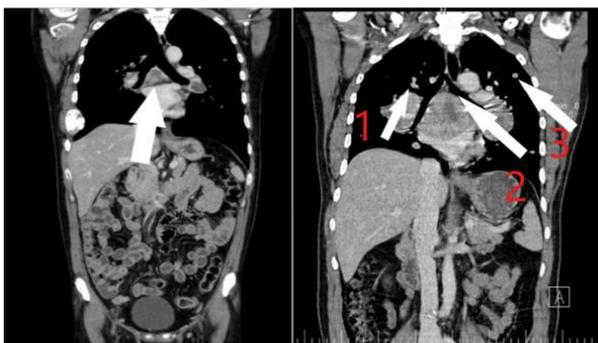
Chest CT images demonstrating radiologic response to mediastinal IMRT in metastatic FTC. Right: Pre-treatment CT showing numerous bilateral pulmonary metastatic nodules (largest approximately 45 mm) and a bulky subcarinal lymph node measuring 50 × 70 mm. Left: Follow-up whole-body CT performed months after scapular metastasis work-up reveals interval regression of thoracic metastatic disease, with the largest pulmonary nodule reduced to 26 mm and the subcarinal lymph node reduced to 38 × 21 mm, confirming durable radiologic response.
